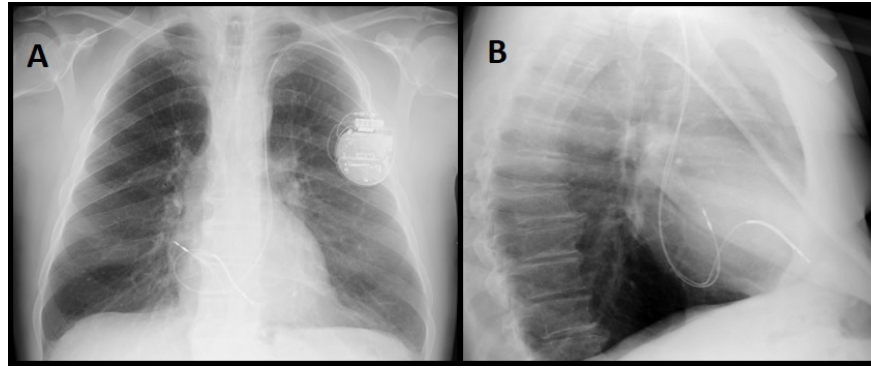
Chest radiograph after ICD implantation (A: posteroanterior view; B: lateral view). The ICD lead is located in the apex of the right ventricle, and the atrial lead in the right appendage.
